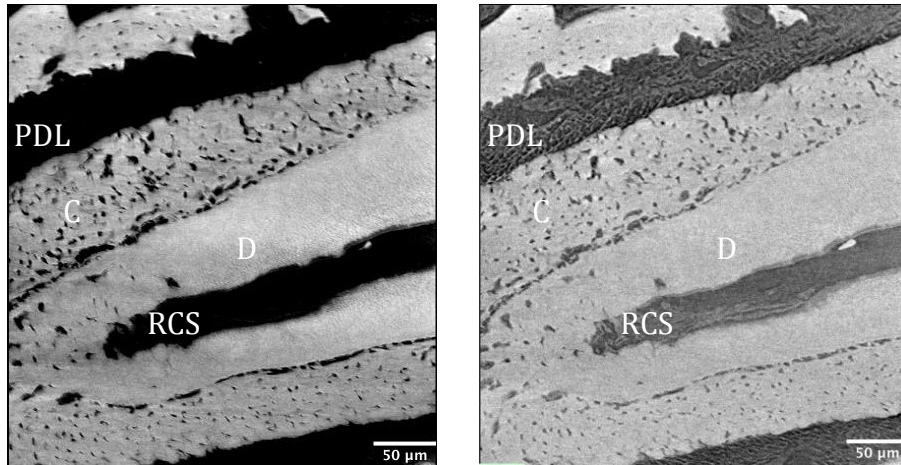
Micro-XCT images of maxilla sample 1-2L-R, depicting A. low energy mosaic radiograph (30 kVp), B. high energy mosaic radiograph (90 kVp), C. dual energy mosaic radiograph (90 kVp – 30 kVp, with an arbitrary 2:1 weighting factor, respectively), D. high resolution, single radiographs of the 2nd molar, mesial root (2-MR) in low, high, and dual energies (left to right), E. Virtual sections taken from 3-D reconstructions of low/high energy (left/right) tomographs of the 1st molar, mesial roots (1-MR). All abbreviations and their corresponding definitions are identical to those presented in Figure 1.
